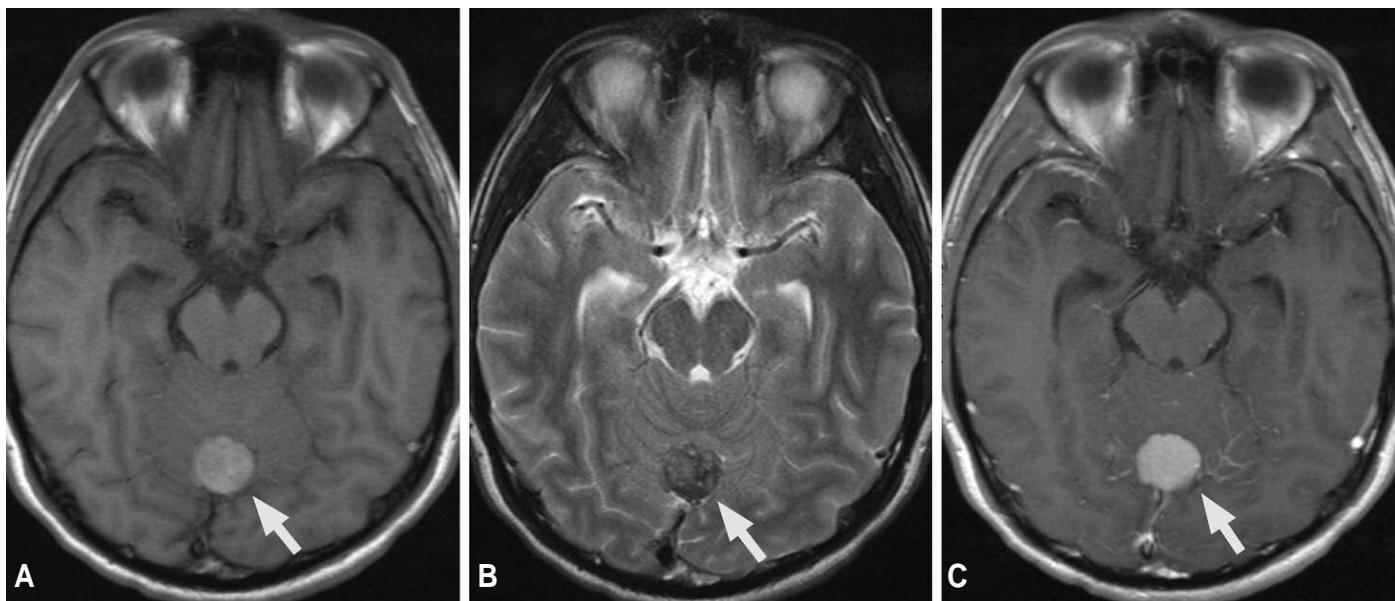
MRI features of melanocytoma. A T1-weighted axial images (pre-contrast) reveal a hyperintense, well-circumscribed mass in the midline of the cerebellum arising from the dura. B On T2-weighted images, the mass is hypointense. C Following the administration of contrast agent, the melanocytoma shows homogeneous enhancement.
